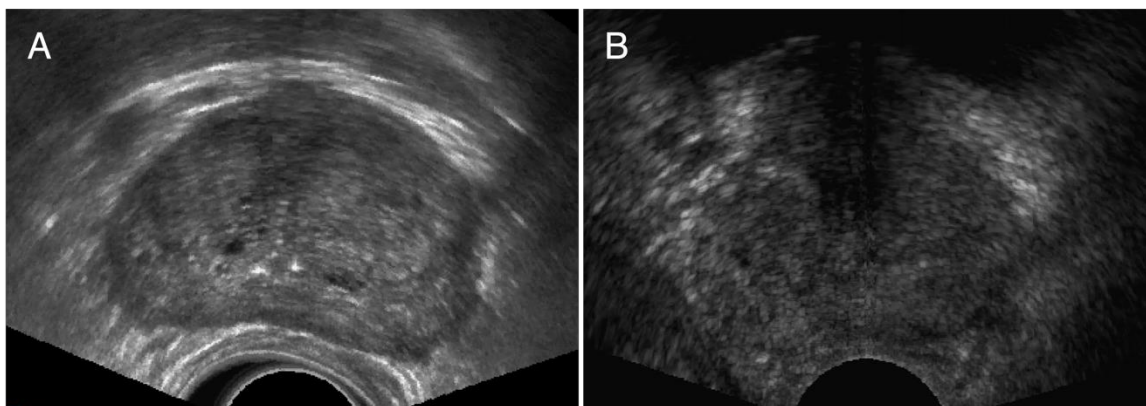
Example transrectal ultrasound images highlighting the variability in image quality and prostate boundary visibility which can make manual prostate segmentation time consuming and difficult. (A) Example high quality image with a clearly defined prostate boundary. (B) Example poor quality image with severe shadowing artifacts that limit the prostate boundary visibility.
